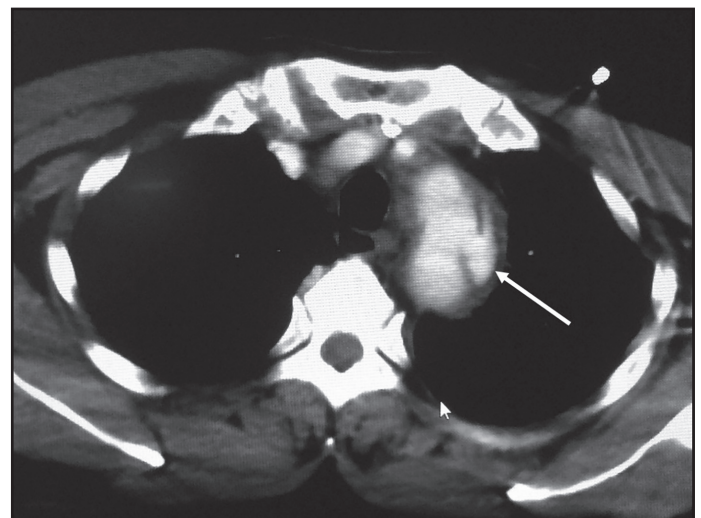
Enhanced chest computed tomography (CT) on arrival. The CT scan shows pseudo-aneurysm at the aortic arch (arrow).
